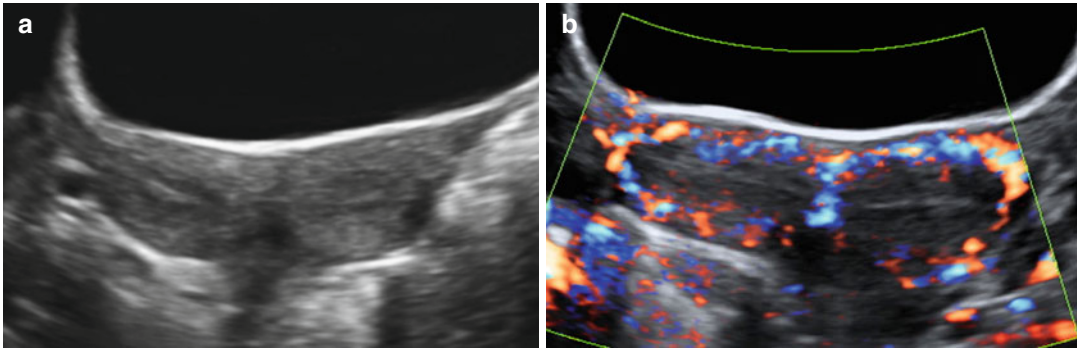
TAS images of a didelphus uterus in transverse section: (a) two separate uterine horns are seen (b) Color Doppler shows a typical uterine vascularization in each
